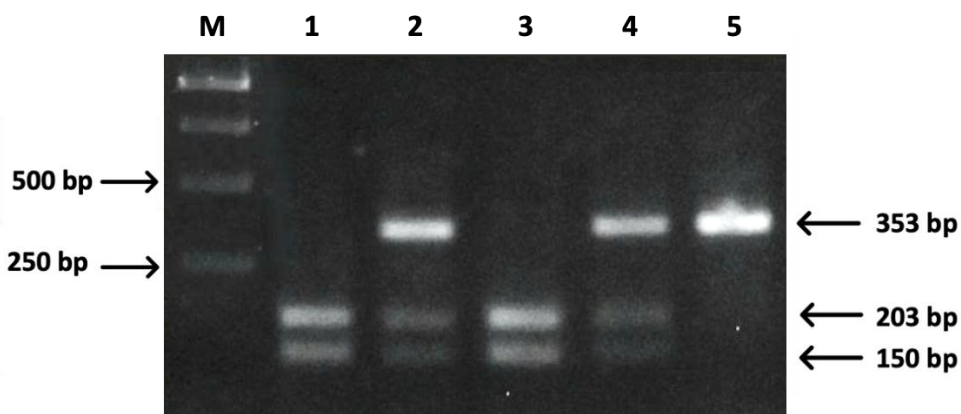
HinfI*-digested PCR products of *SHBG* rs727428 on a 2.5 % agarose gel. M: Marker 1 kbp (Thermo Fisher); 1, 3: Wild-type CC (2 bands of 203 bp and 150 bp); 2, 4: Heterozygous CT (3 bands of 353 bp, 203 bp, and 150 bp); 5: Homozygous TT (1 band of 353 bp).
